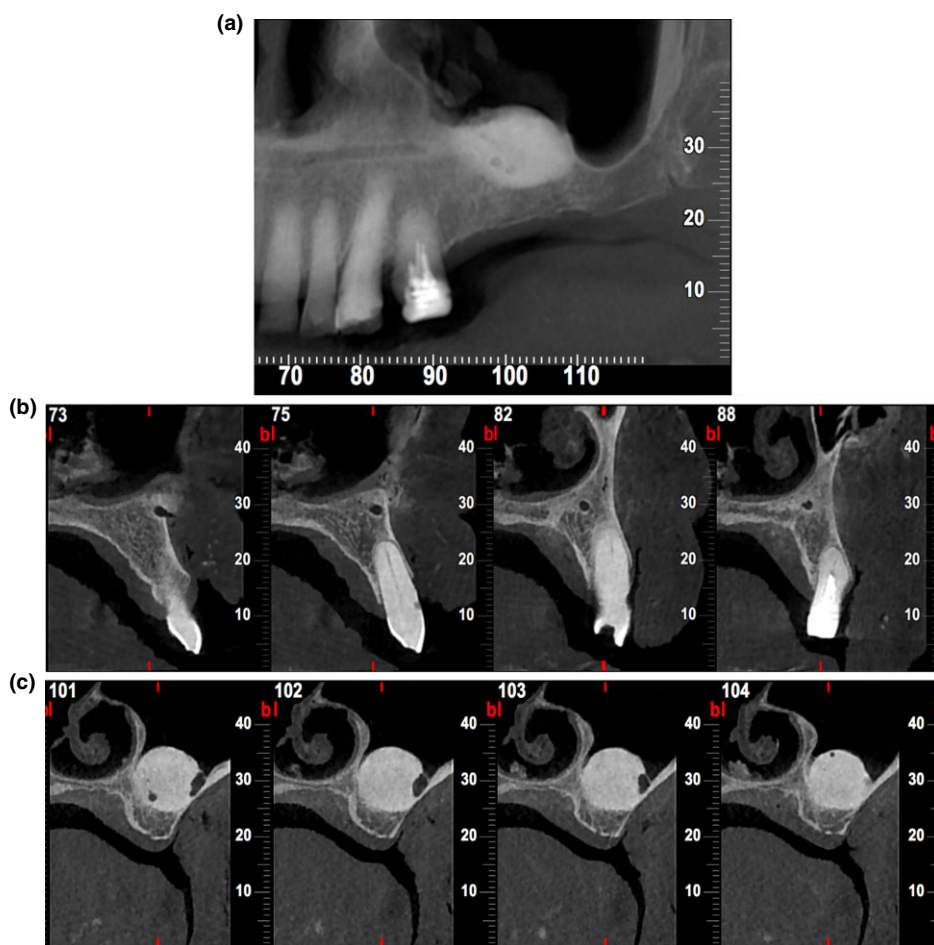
Post-operative Cone beam CT (panoramic (a) and radial views). In the toothed maxillary anterior sector (b), the approach under the nasal floor to access to maxillary sinus floor can be followed on radial views. In the edentulous maxillary posterior sector (c), the dome shape provides a greater amount of submucosal space augmentation to the atrophic maxillary ridge. This facilitates implant planning to allow use of the largest possible implant.
